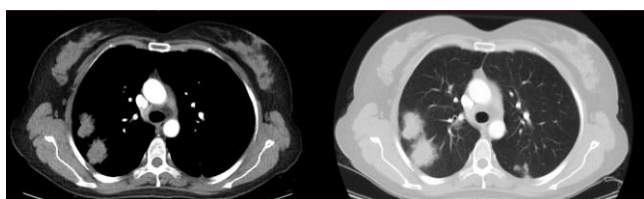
Thoracic CT showing two lesions with soft tissue densities in the right upper lung lobe
